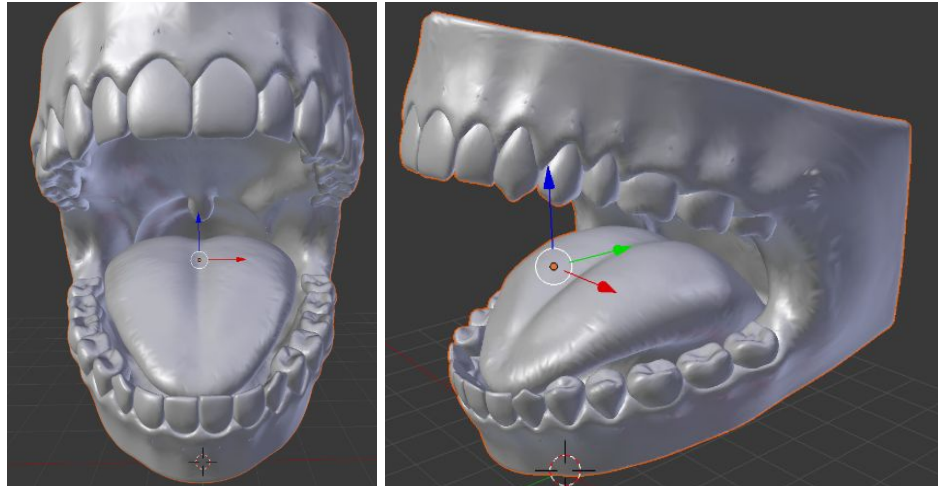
The CT reconstructed upper respiratory tract once the outer shell was removed.
